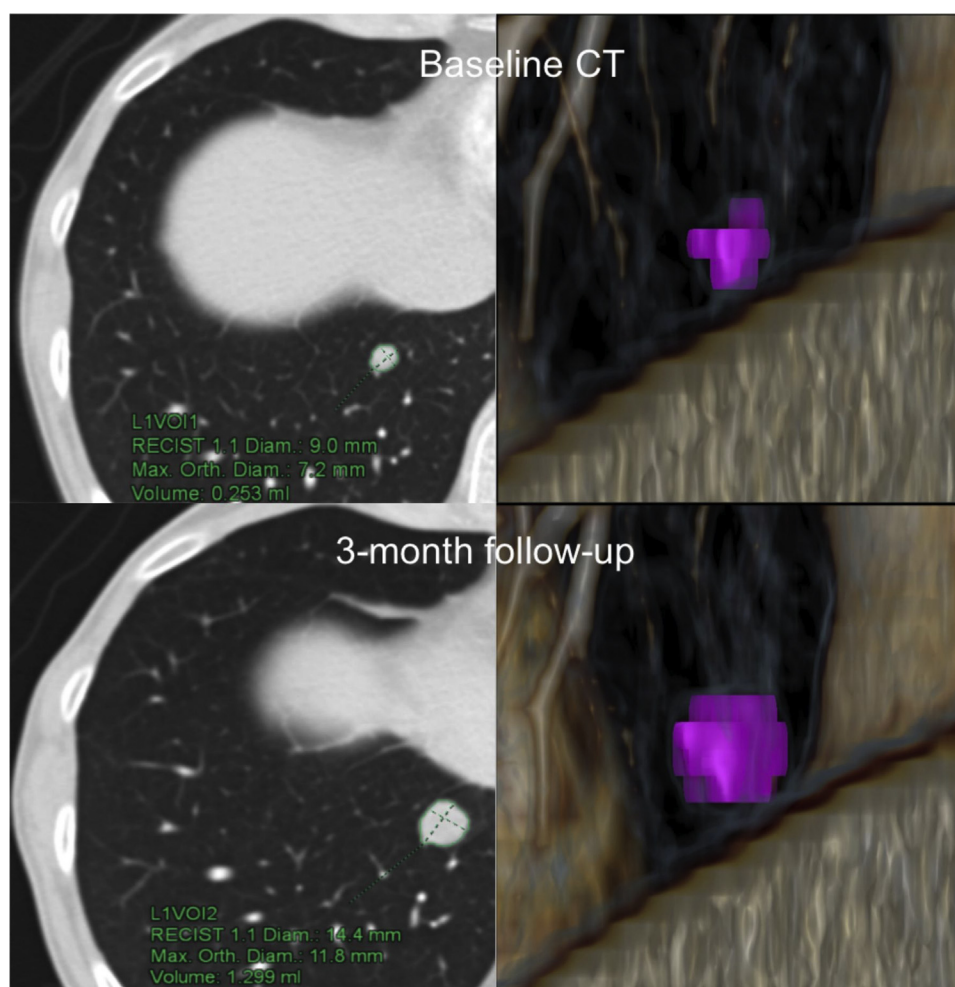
Low-dose computed tomography (CT) scan of a 58-year-old male patient with 67 pack-years of smoking who underwent lung cancer screening. A fast-growing pulmonary nodule with a volume-doubling time of 95 days was detected. An additional positron emission tomography-CT scan showed no malignant uptake in lymph nodes or metastatic disease. The patient underwent anatomical surgical resection and systemic mediastinal lymph node dissection. RECIST, Response Evaluation Criteria in Solid Tumors; Max., maximum; Orth., orthogonal; Diam., diameter.
